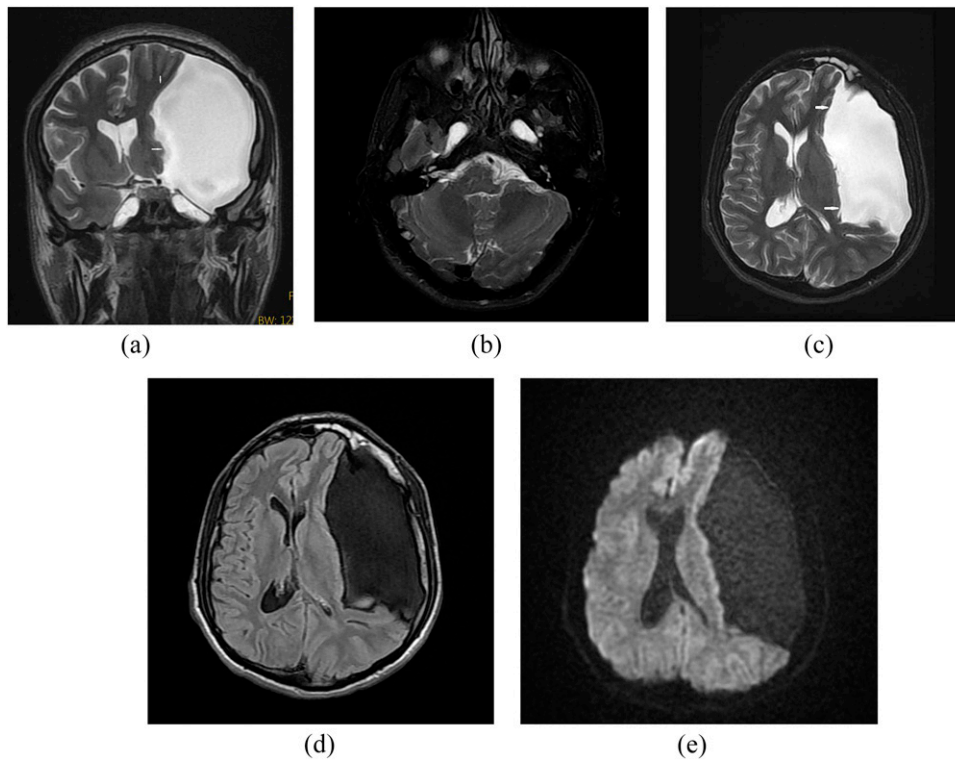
A 26-year-old male complaining of headaches. Coronal T_2 weighted (a) and axial T_2 weighted (b) MR images show bilateral petrous apex cephalocele. Coronal (a), axial T_2 weighted (c), axial fluid-attenuated inversion recovery (d) and diffusion-weighted (e) MR images show coexistent arachnoid cyst (arrows) on the left side.
